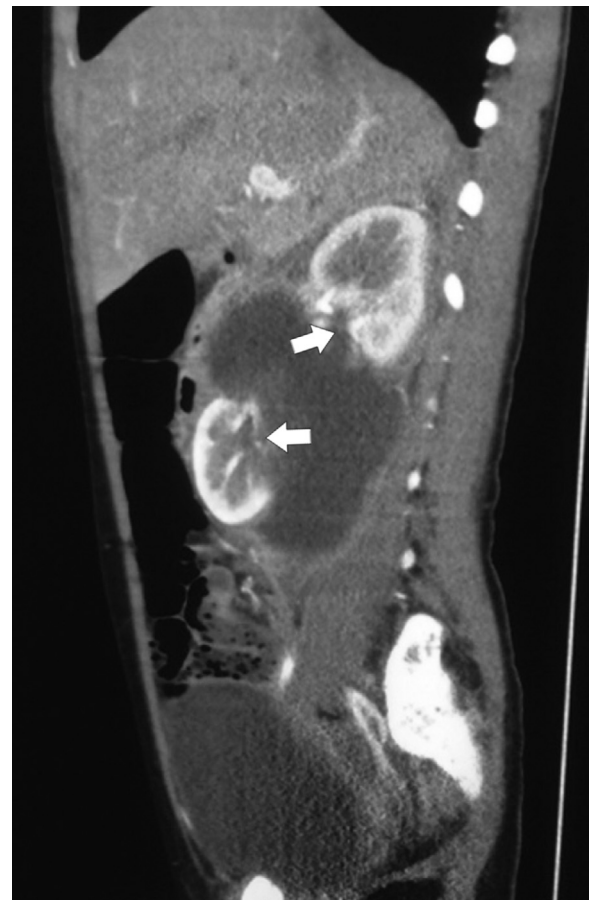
Sagittal view of the contrast-enhanced abdominal CT indicating a mid-posterior rupture and urinoma.
